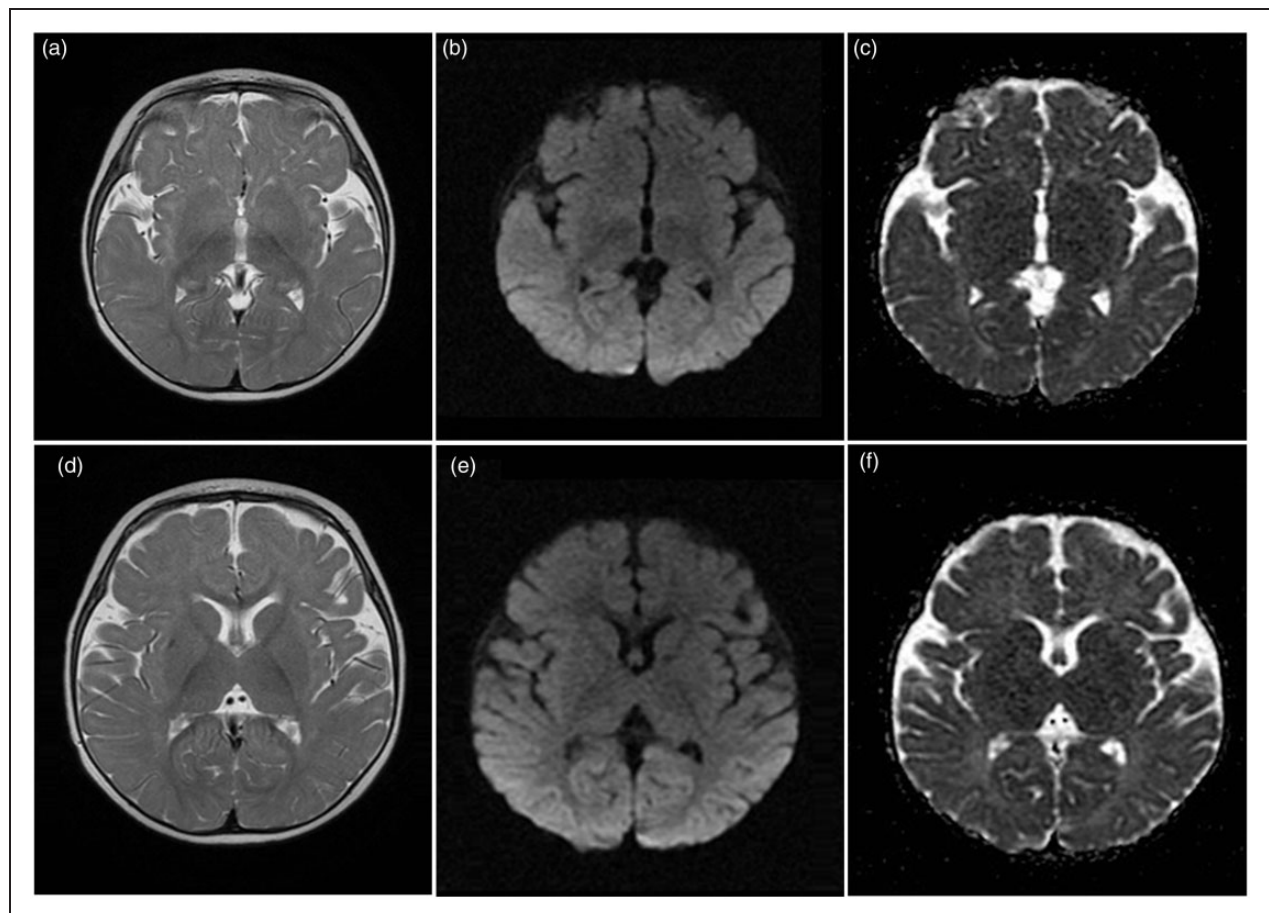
Follow-up MRI six months later shows no alteration in the previously affected deep gray matter. Cerebral atrophy is less pronounced than at the initial scanning. MRI: magnetic resonance imaging.
